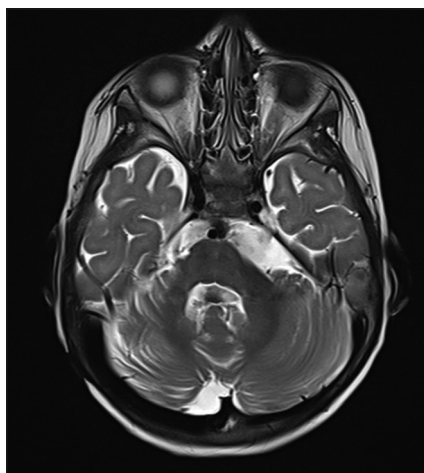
Post op magnetic resonance imaging showing gross total excision
